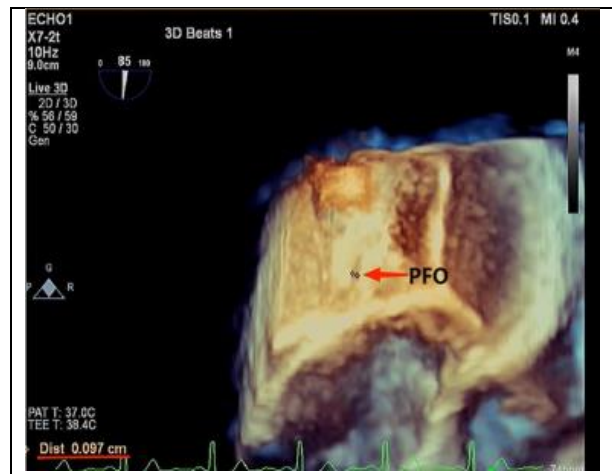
Transesophageal Heart Three-Dimensional Echocardiography: After the Valsalva manoeuvre, the atrial septum's ovoid fossa measured about 0.9 mm wide.
